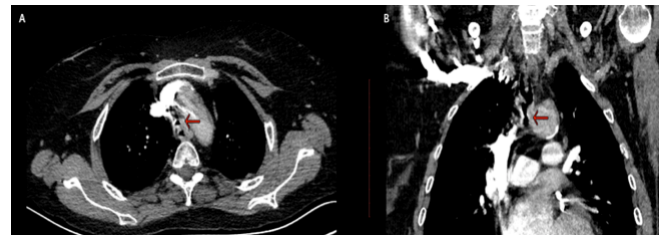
Axial (A), and coronal (B) CT images showing tracheal stenosis (arrows).
